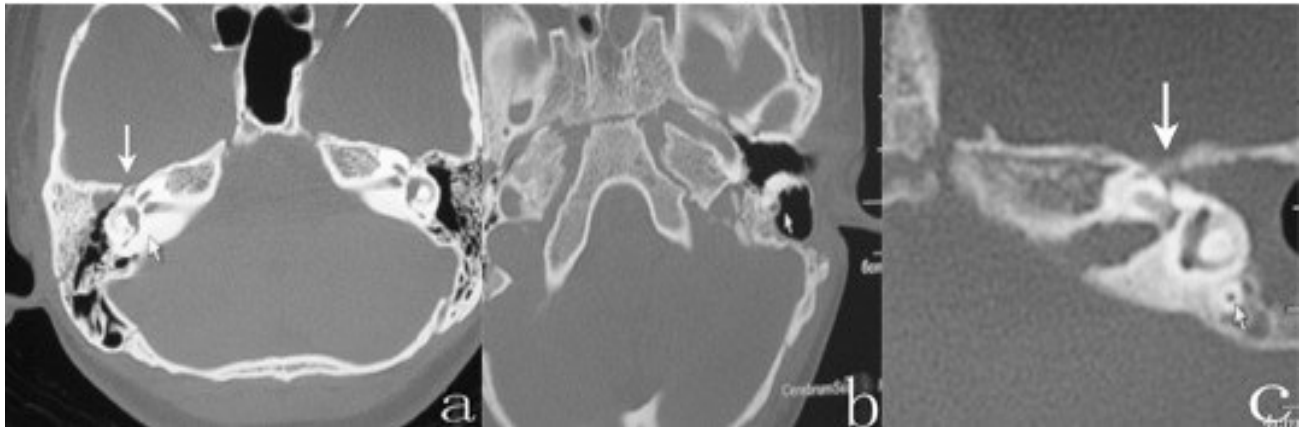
a. injury site around the geniculate ganglion in a case of right temporal bone fracture (arrowhead). b. post-operative HRCT showing vertical segment facial nerve decompression for traumatic FP. c. postoperative HRCT showing nerve decompression in the left geniculate ganglion and distal labyrinthine segments via a mastoid–epitypanum approach (arrowhead).
